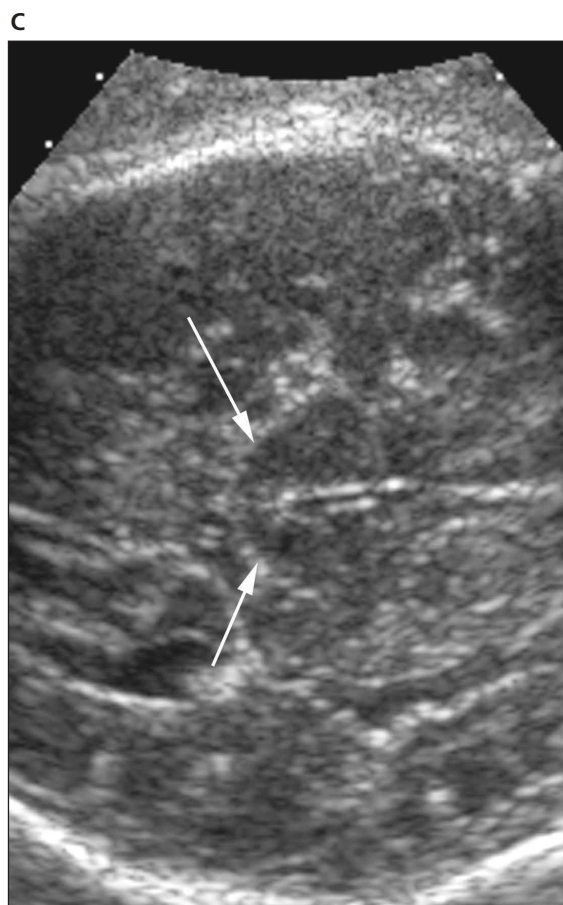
A–C, Axial sonograms of the fetal brain at various stages in pregnancy from the early second trimester (A) into the third trimester (C). Note that the tectum, marginated by the brightly echogenic ambient and quadrigeminal plate cisterns (arrows), is short and either somewhat squared or rounded. Contrast these normal shapes with the abnormal tectal plates seen in the Chiari II malformation.
